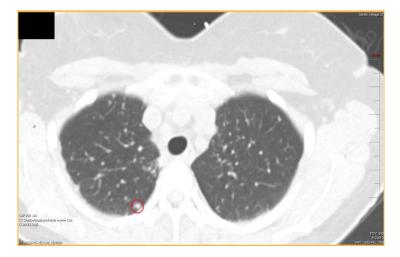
Non-contrast CT showing bilateral pulmonary nodules in the upper lobes, largest of which marked by the red circle
